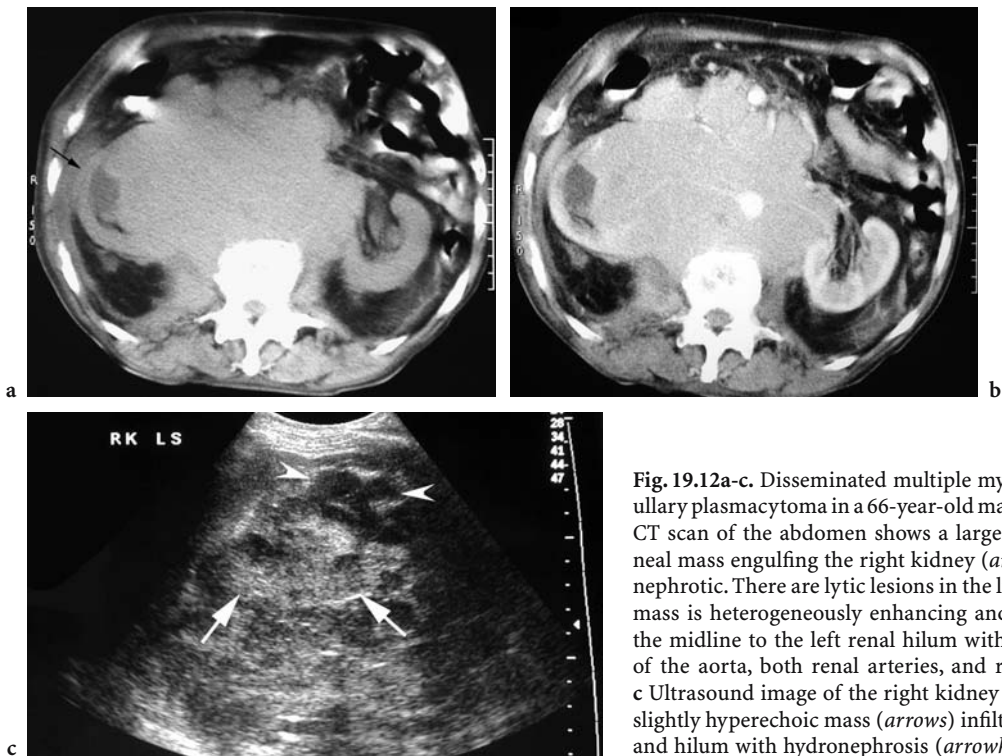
Disseminated multiple myeloma and extramedullary plasmacytoma in a 66-year-old man. a Axial unenhanced CT scan of the abdomen shows a large isodense retroperitoneal mass engulfing the right kidney (arrow), which is hydronephrotic. There are lytic lesions in the lumbar vertebrae. b The mass is heterogeneously enhancing and has extended across the midline to the left renal hilum with vascular encasement of the aorta, both renal arteries, and root of the mesentery. c Ultrasound image of the right kidney shows heterogeneous, slightly hyperechoic mass (arrows) infiltrating the renal pelvis and hilum with hydronephrosis (arrowheads).
